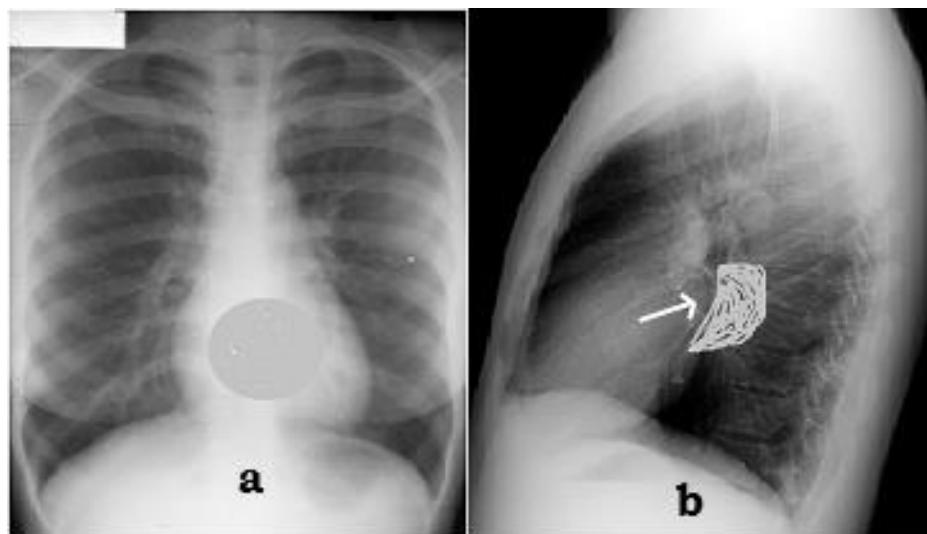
Chest radiographs showing how the left atrium enlarges. a. Postero-anterior view and b. lateral view
